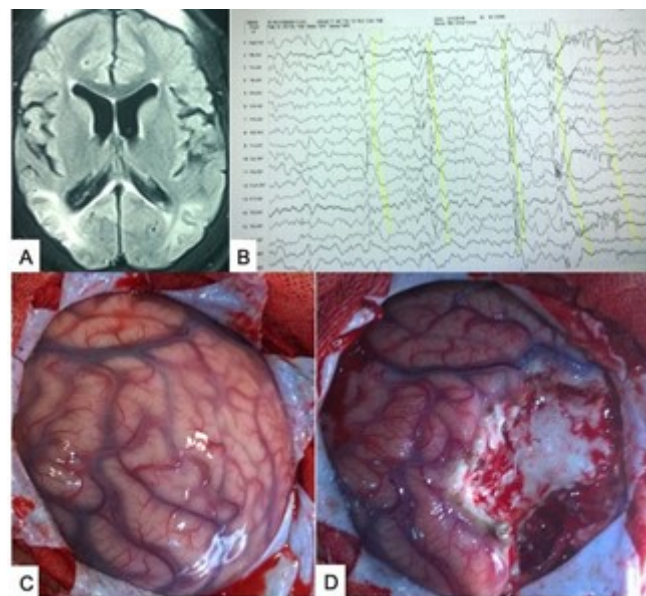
(A) MRI of brain axial view showing post-viral-infection occipital gliosis and atrophy (right > left) with resistance epilepsy with a history of repeated severe head injury due to falls. (B) EEG showing abnormal electrical discharges predominantly from the right occipital area. (C,D) Peroperative pictures of right occipital focal excision (patient was hemianopic). Surgical excision eased seizure control with drugs. Source: Figure by authors.
